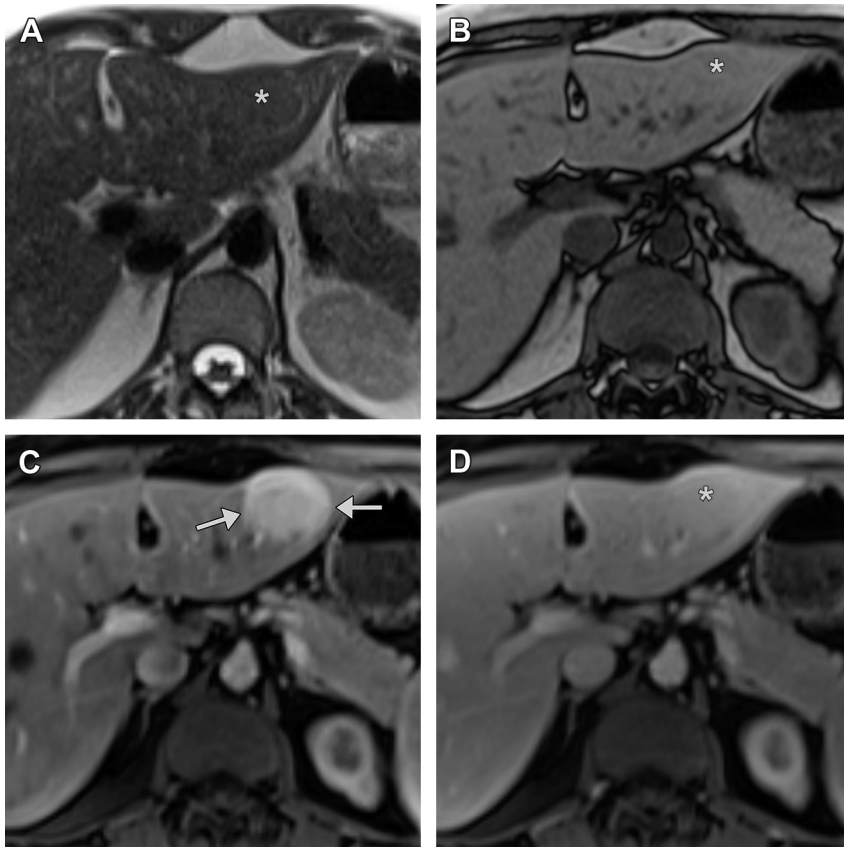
FNH as “stealth” lesion. (A) There is a slight contour bulge of the lateral left hepatic lobe due to an underlying T2 isointense mass (*asterisk*). (B) The mass is isointense to liver on opposed-phase T1-weighted imaging (*asterisk*), unlike a fat-containing lesion. (C) It demonstrates uniform arterial hyperenhancement (*arrows*). (D) It then fades to become nearly isointense to liver during portal venous phase (*asterisk*).
